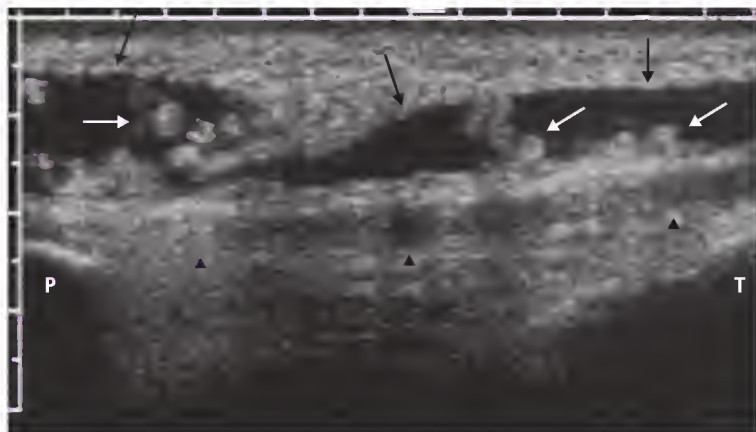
Longitudinal ultrasound image anterior to the knee along the patellar tendon. A large fluid collection (black arrows) is located anterior to the patellar tendon (arrowheads) in the prepatellar and infrapatellar bursae along with areas of synovial hypertrophy (white arrows). P, patella; T, tibial tuberosity.
